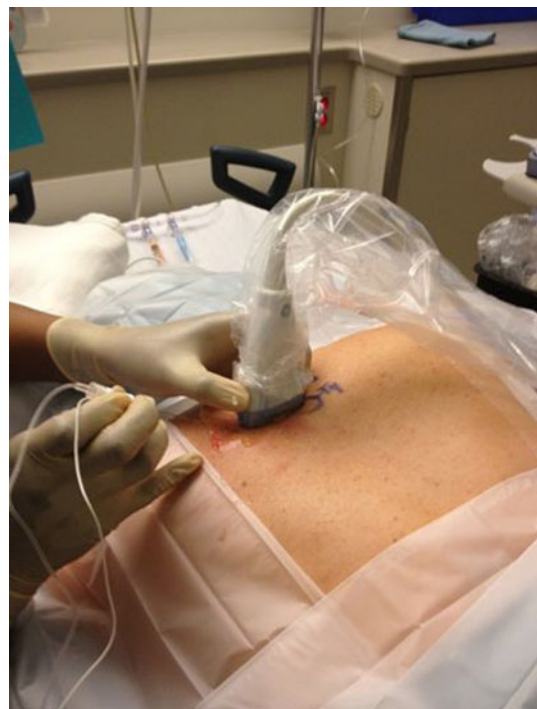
Ultrasound-guided paravertebral block placement
